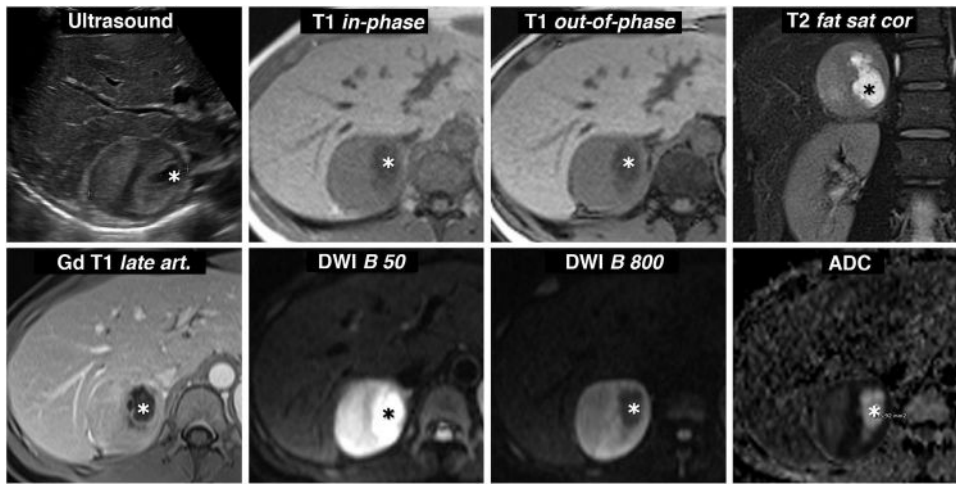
Pheochromocytoma with cystic changes and high signal on T2. Ultrasound and MRI 30-year-old woman with severe headache who required admission to the ICU for a hypertensive emergency. Ultrasound revealed a practically spherical right adrenal mass, perfectly delimited, with small cystic foci (*) and heterogeneous echogenicity in the solid areas, with some areas more echogenic and others hypoechoic. Pheochromocytoma was suggested in the ultrasound diagnosis. The appearance on MR is also characteristic, with predominant solid areas with high signal on T2-weighted images (compare with that of the paravertebral musculature), which enhance intensely and do not show signal drop out-of-phase. There is a correlation between the most hypoechoic areas and the areas with greater restriction of water diffusion, which maintain a higher signal in the diffusion-weighted sequence with high B value and are markedly hypointense in the parametric ADC map (with values of $0.7 \times 10^{-3} \text{ mm}^2/\text{s}$). The cystic areas are hypointense on T1, hyperintense on T2, do not enhance and show facilitated water diffusion, with a large drop in signal with high B value and ADC of $2.2 \times 10^{-3} \text{ mm}^2/\text{s}$.
